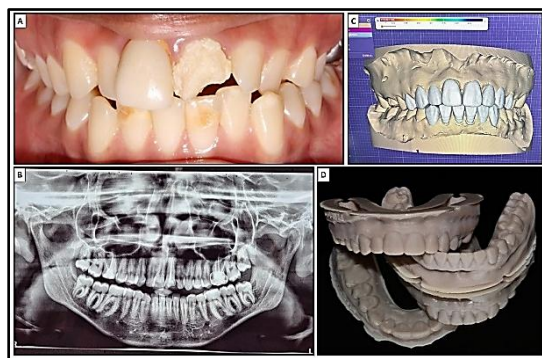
A) Pre-operative intraoral photograph; B) Pre-operative orthopantomogram; C) Digital smile designing; D) 3D-printed Models.
